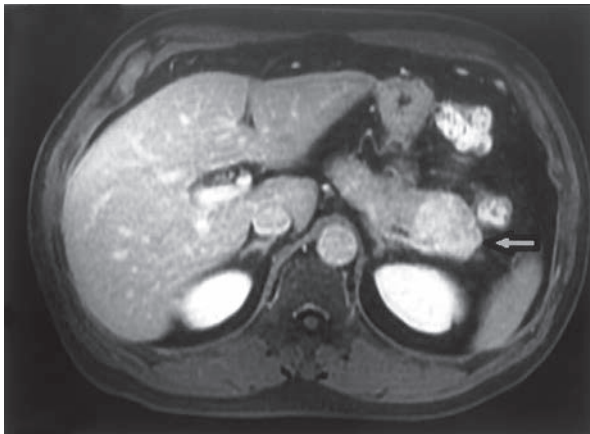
Axial contrast-enhanced MRI scan shows a heterogeneously-enhanced nodule in the pancreatic tail.
